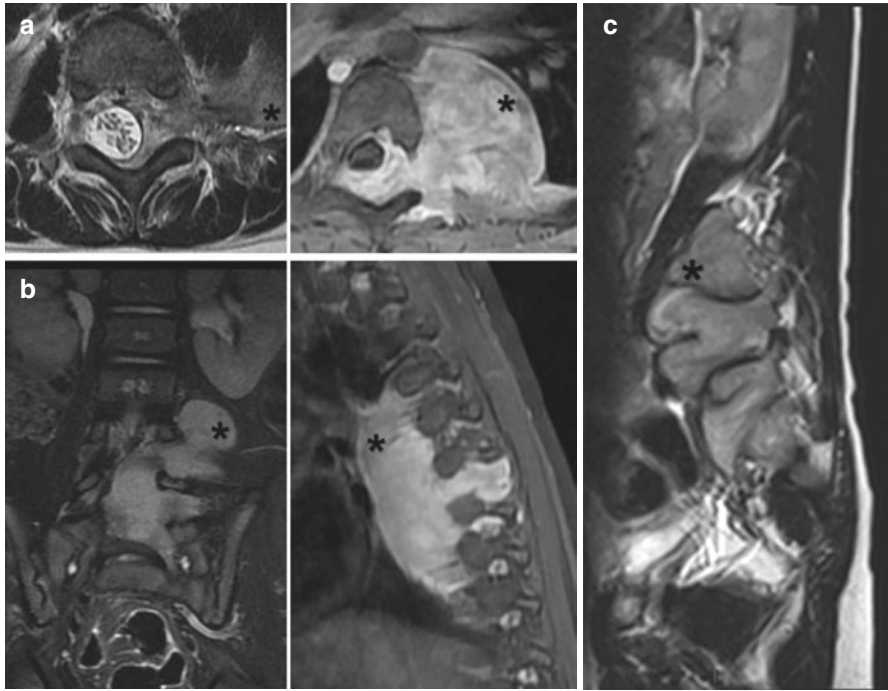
Magnetic resonance imaging with spinal canal involvement. (a) Axial section; (b) coronal section. (c) sagittal section
